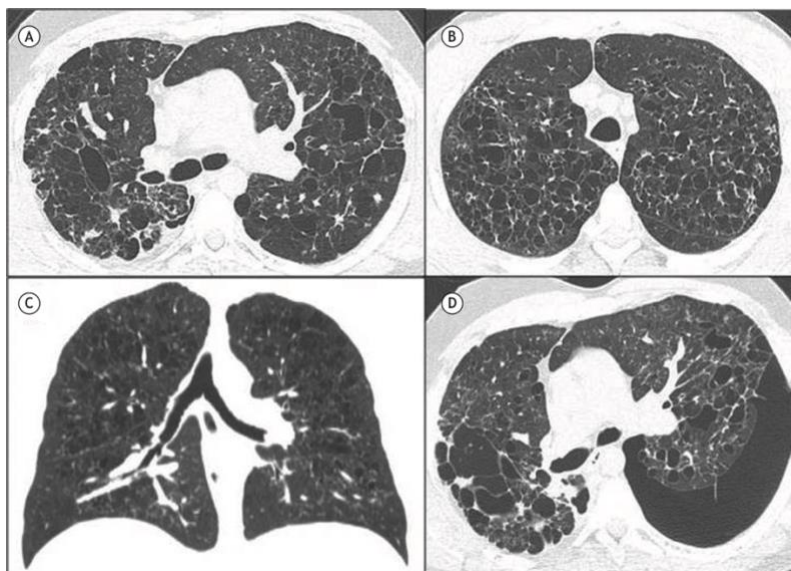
CT scan images of a patient with PLCH. In A, irregular cysts, irregularly circumscribed centrilobular nodules in the upper lobe (axial section). In B, irregular thin-walled cysts (axial section). In C, irregular cysts predominate in the upper lobe and spare the costophrenic sinus area (coronal section). In D, irregular cysts, multiple centrilobular nodules, and a left pneumothorax (axial section); Adapted from Baldi et al.¹¹, under the Creative Commons Attribution license.
